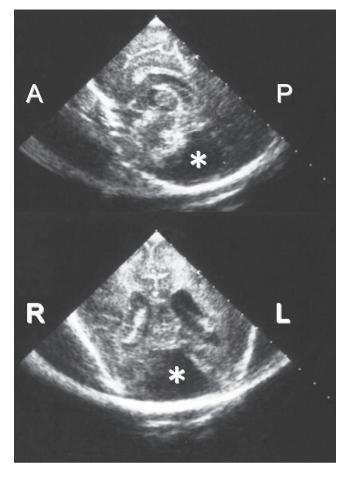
Brain ultrasonography. Brain ultrasonography (upper; sagittal image/lower; axial image) showed enlarged lateral ventricles associated with hypoplasia of the cerebellar vermis (\*). A, anterior; P, posterior.
